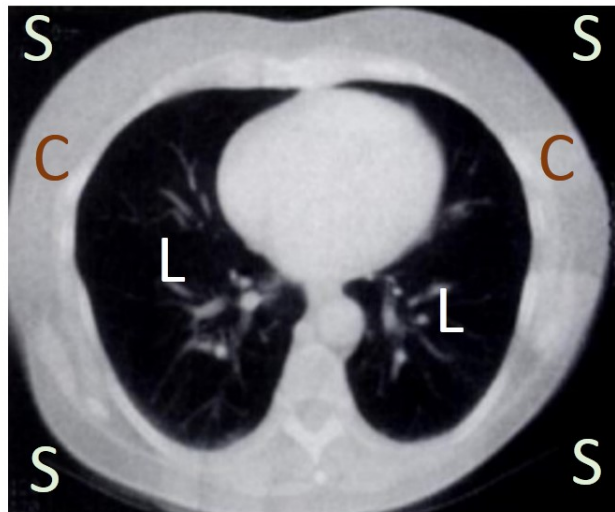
Axial CT slice of the thoracic region. The regions marked ‘L’ are the lungs. The region marked ‘C’ are the chest structures. The regions marked ‘S’ are the background surrounding the chest wall. Image from [34]
